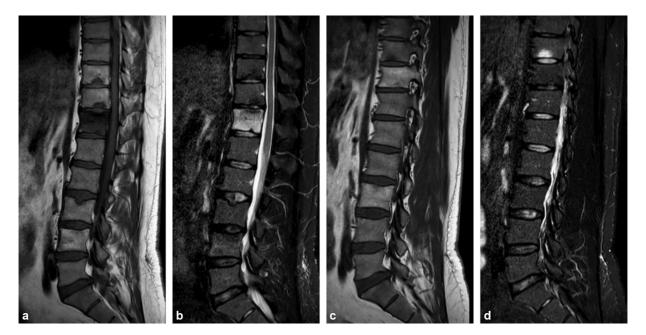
Sagittal T1-weighted turbo spin-echo (T1TSE) and short tau inversion recovery (STIR) images (a,b after two years; c,d at baseline). (c, d) Showing the chronic inflammatory pattern of relapsing osteitis in a 43-year-old man with SAPHO. The bone marrow edema (BME) in vertebra T12 is new (b); multiple end plates developed irregular height loss (a, b). Note the previous BME in end plate T10.
